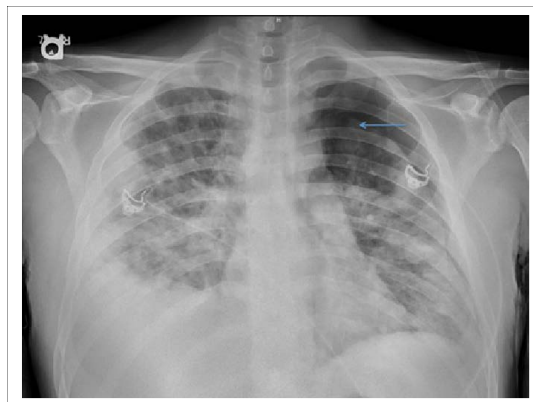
Bilateral pulmonary infiltrates on chest x-ray.
